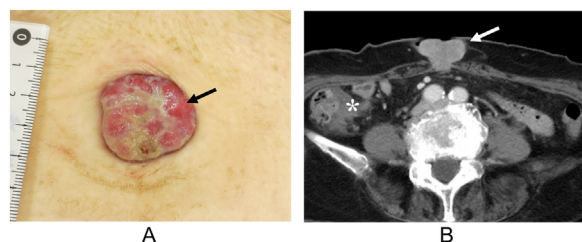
An older, frail woman in her 90s with Sister Mary Joseph's nodule was referred for radiation therapy. (A) The patient had a tumor (3 × 3.5 cm) (black arrow) in the umbilical region. (B) Computed tomography revealed a tumor (white arrow) extending from the skin to the peritoneum within the umbilical region and a thick cecal wall (*).
